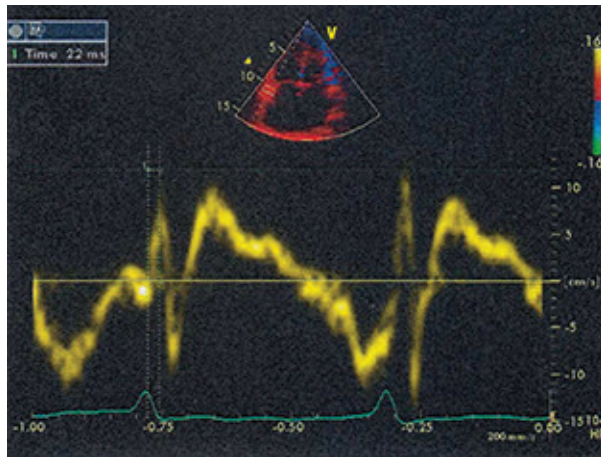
Tissue Doppler study of right ventricular function before surgery in patients without subvalvular apparatus preservation during MVR.
